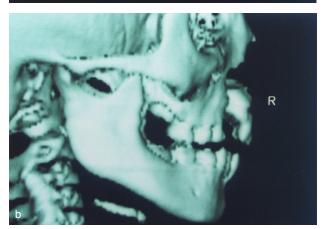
a): Preoperative 3D computed tomography b): Postoperative 3D computed tomography
